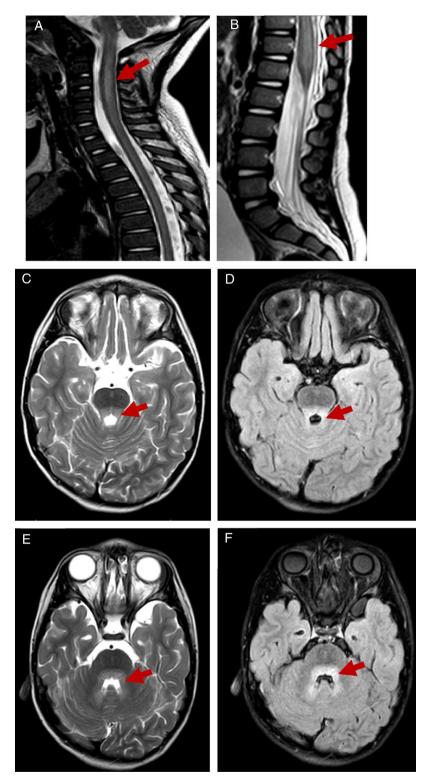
T2-weighted and FLAIR MR images showing hindbrain involvement with myelitis. T2-weighed images showing hyperintensity on at the level of the cervical spine until segment C6 in patient 2 (A) and significant thickening of the conus medullaris in patient 4 (B). Hyperintensity on T2-weighted and FLAIR MR images at the level of the posterior pons and surrounding the fourth ventricle in patient 2 (C-F).
